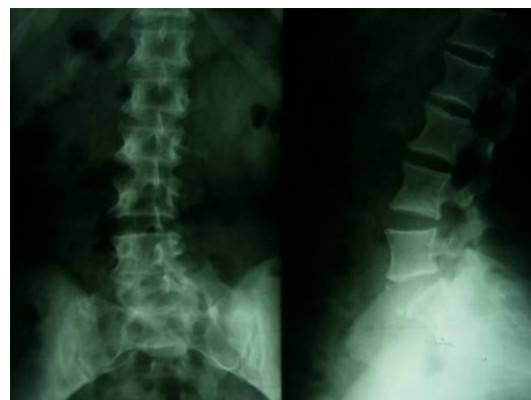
Patient's 1 spine X-Rays. Radiographs show scoliosis at the lumbar segment.
